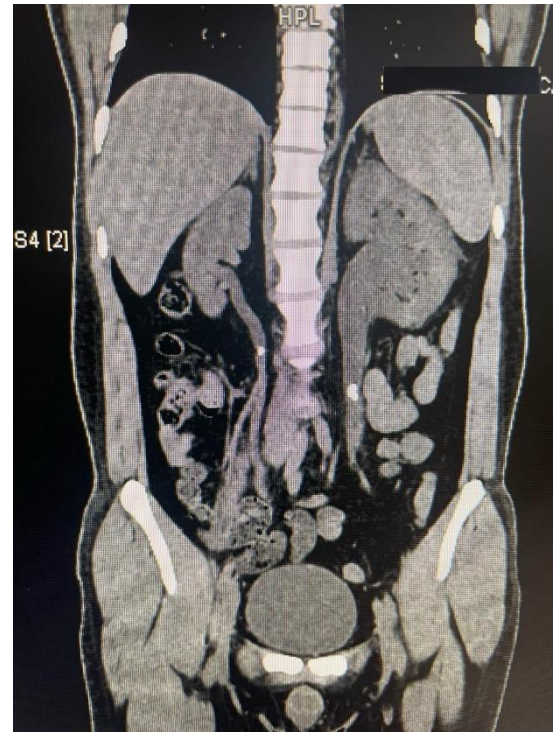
Non impacted ureteric stones found on ureteroscopyFig. 2: Impacted uretric stones found on ureteroscopyFig.3: Coronal view of CT abdomen showing nonimpacted bilateral ureteric stones (nonimpacted stone as per ureteroscopy) with distal ureteric soft tissue density of 19HU(Hounsefield Units) on the right side and 18HU on the left side
